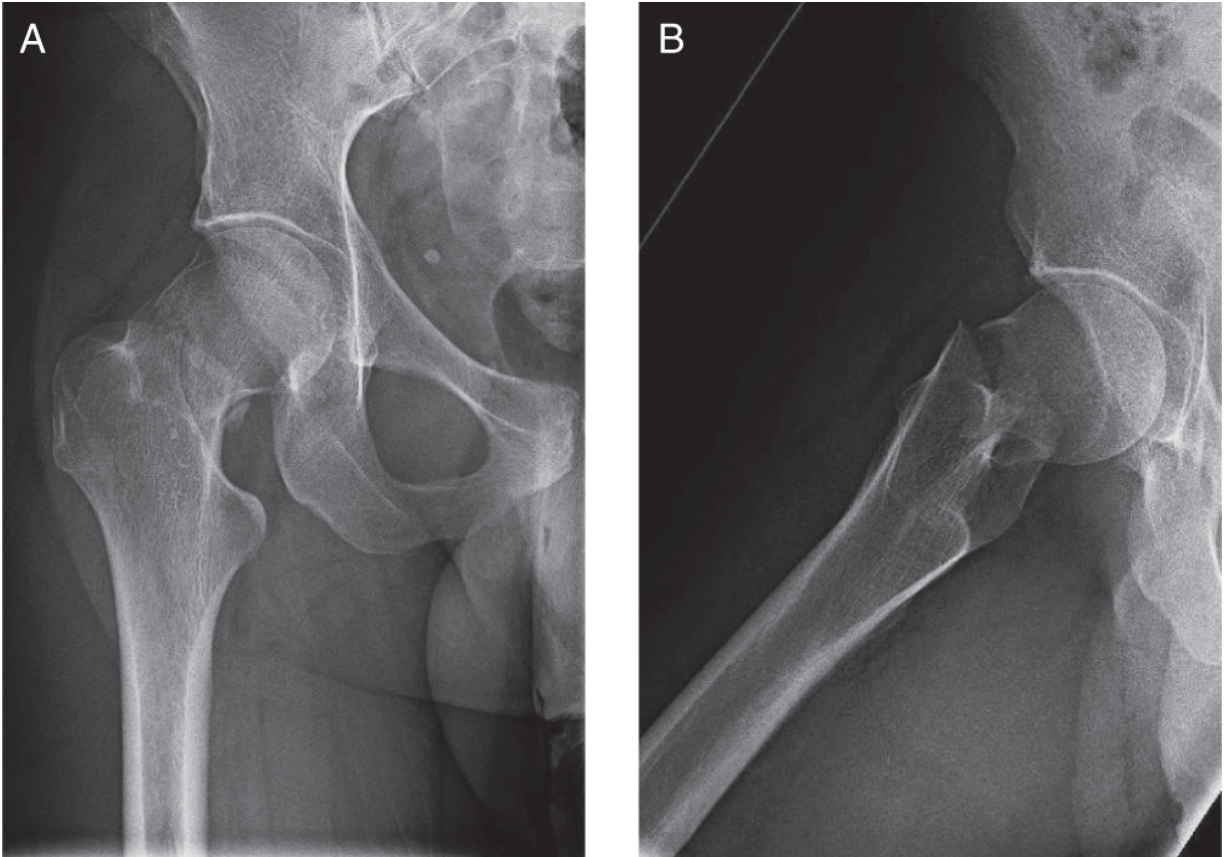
Radiographs on presentation showing right femoral neck fracture: (A) AP right hip; (B) lateral right hip.
